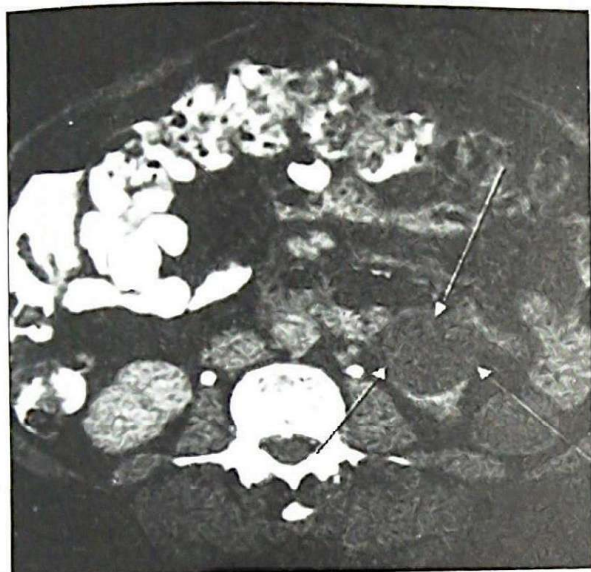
Transverse CT section showing left upper pole renal cyst surrounded by white arrows.
